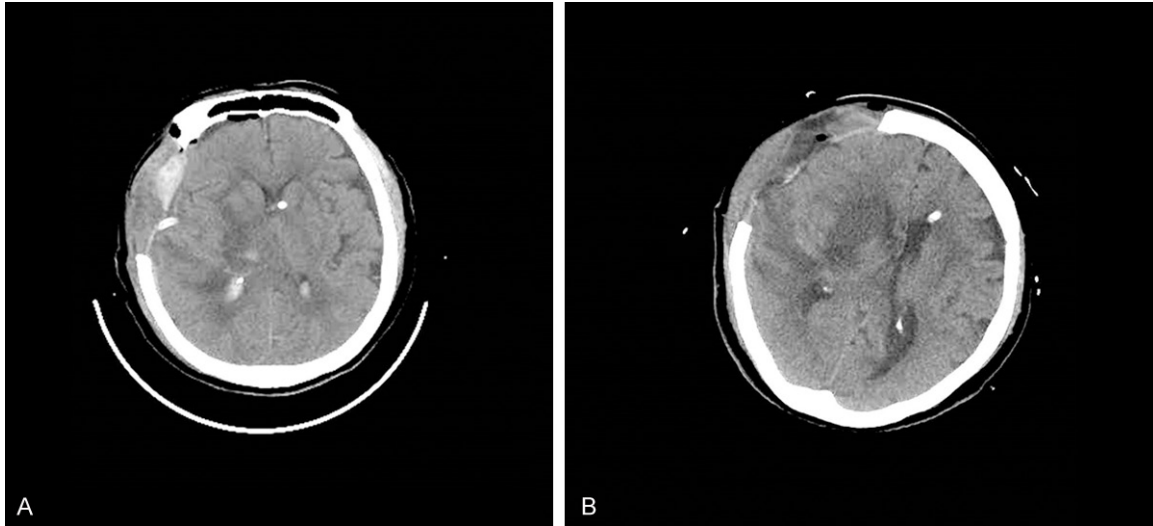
Case 1: A. 5 days after right basal ganglia intracerebral hematoma plus bone flap decompression operation, that the brain CT showed in the brain hematoma was satisfied; B. 10 days after operation it was found in patients with bilateral mydriasis, recheck brain CT showed intracranial no hemorrhage, hydrocephalus.
